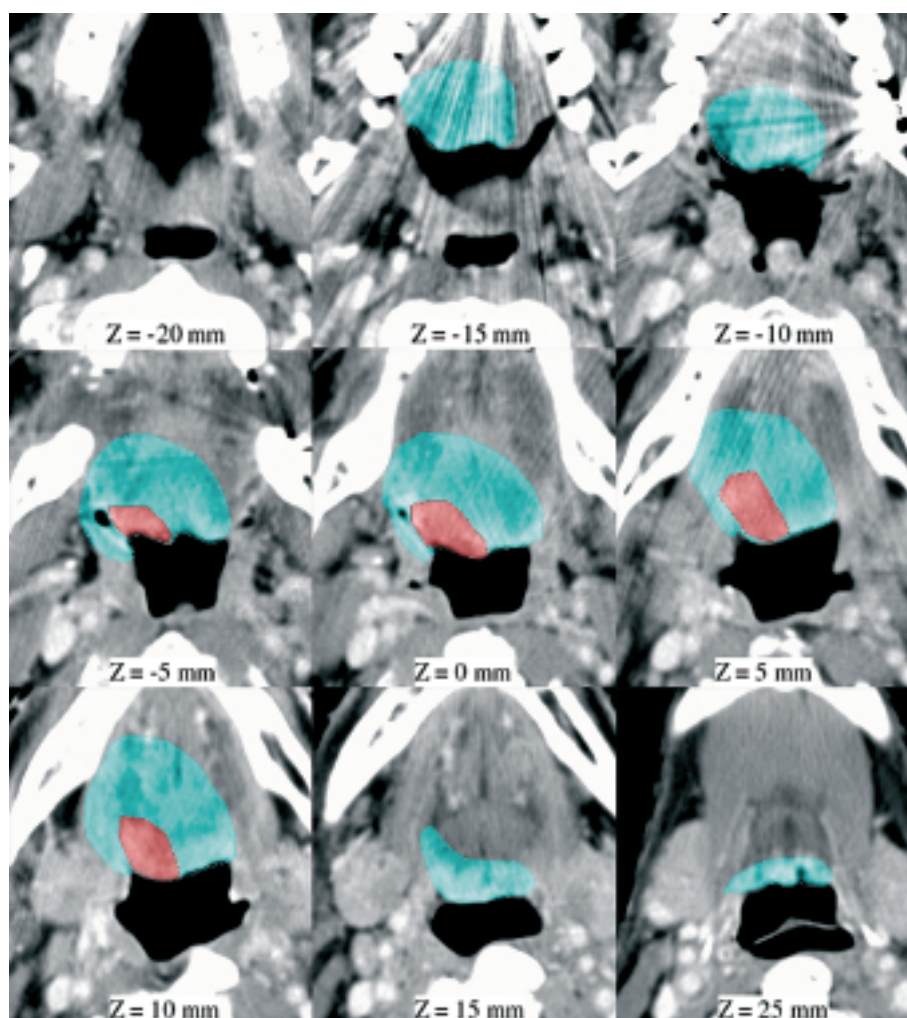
Axial CT slices of a 83y male with a T2 tumor of the right part of the base of tongue (GTV in red). The CTV (in light blue) encompasses the mucosa of base of tongue, a 15 mm extension into the mobile tongue and the Glossotonsillar sulcus.
